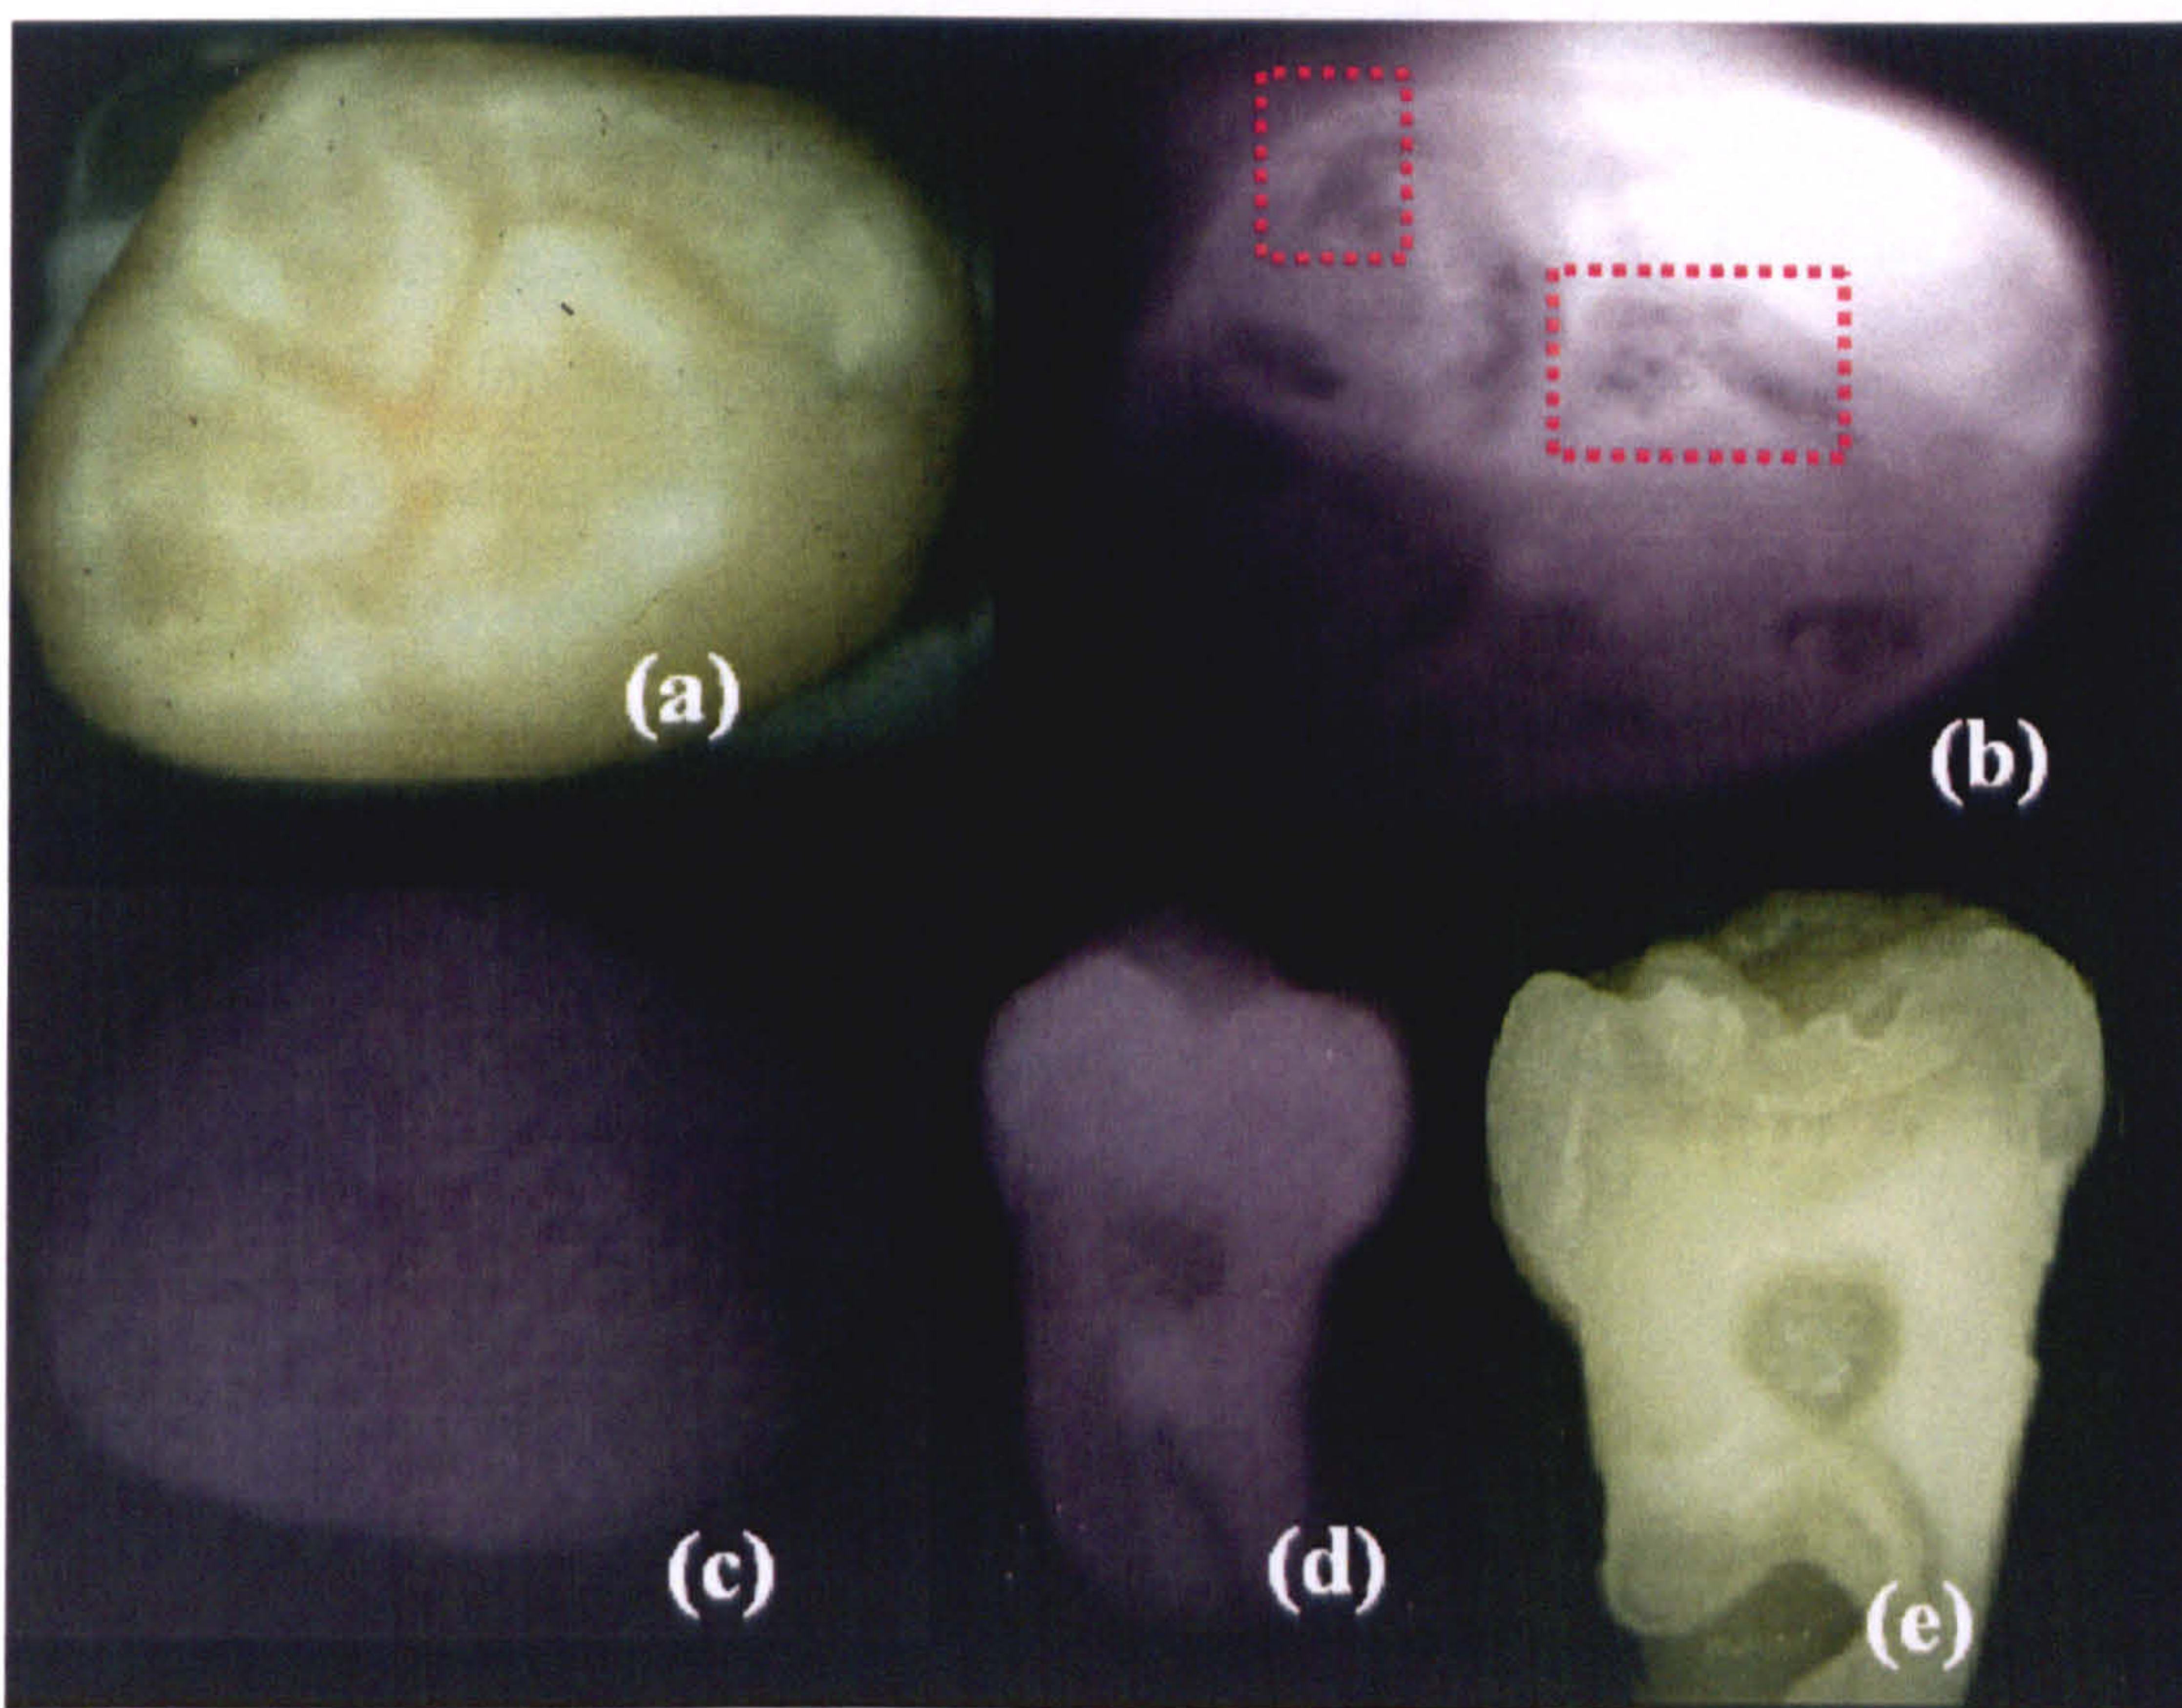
Showing *Sound 1* which contains hypomineralisation (a) Visual Inspection, (b) Lateral Illumination, (c) QLF, (d) Bitewing X-ray photography, (e) Visual Inspection after dissection.
